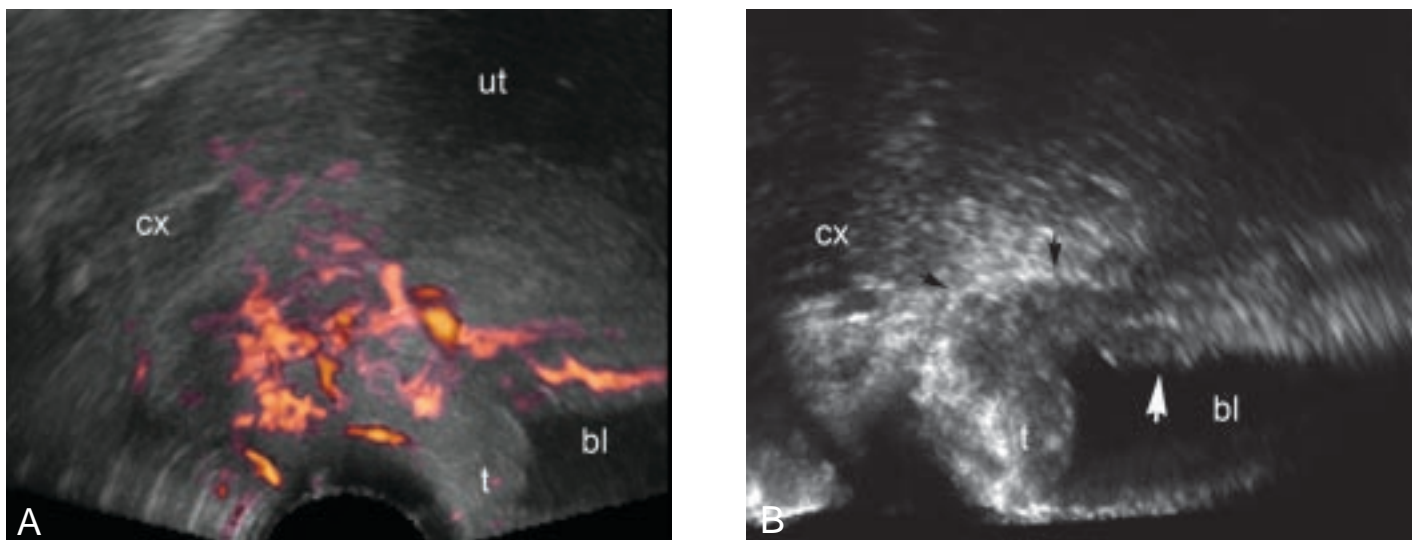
Transvaginal ultrasonography demonstrates that a hypervascular tumor infiltrates the cervix, trigone and posterior bladder wall (A) and that the echogenic boundary between the cervix and posterior bladder wall is lost (black arrows) (B). There is a polypoid projection (white arrow) located in the posterior bladder wall over the trigone. (ut = uterine corpus; cx = cervix; bl = bladder; t = trigone)
